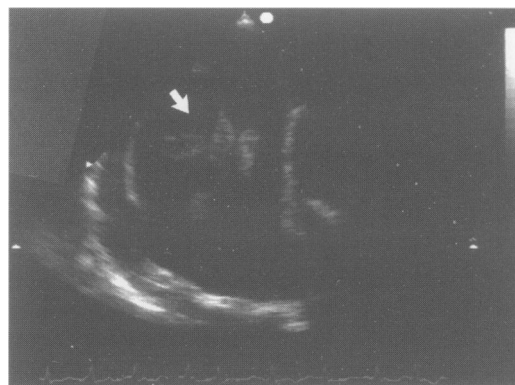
Figure Transoesophageal echocardiogram (transverse view) showing thrombus within a dilated right atrium
